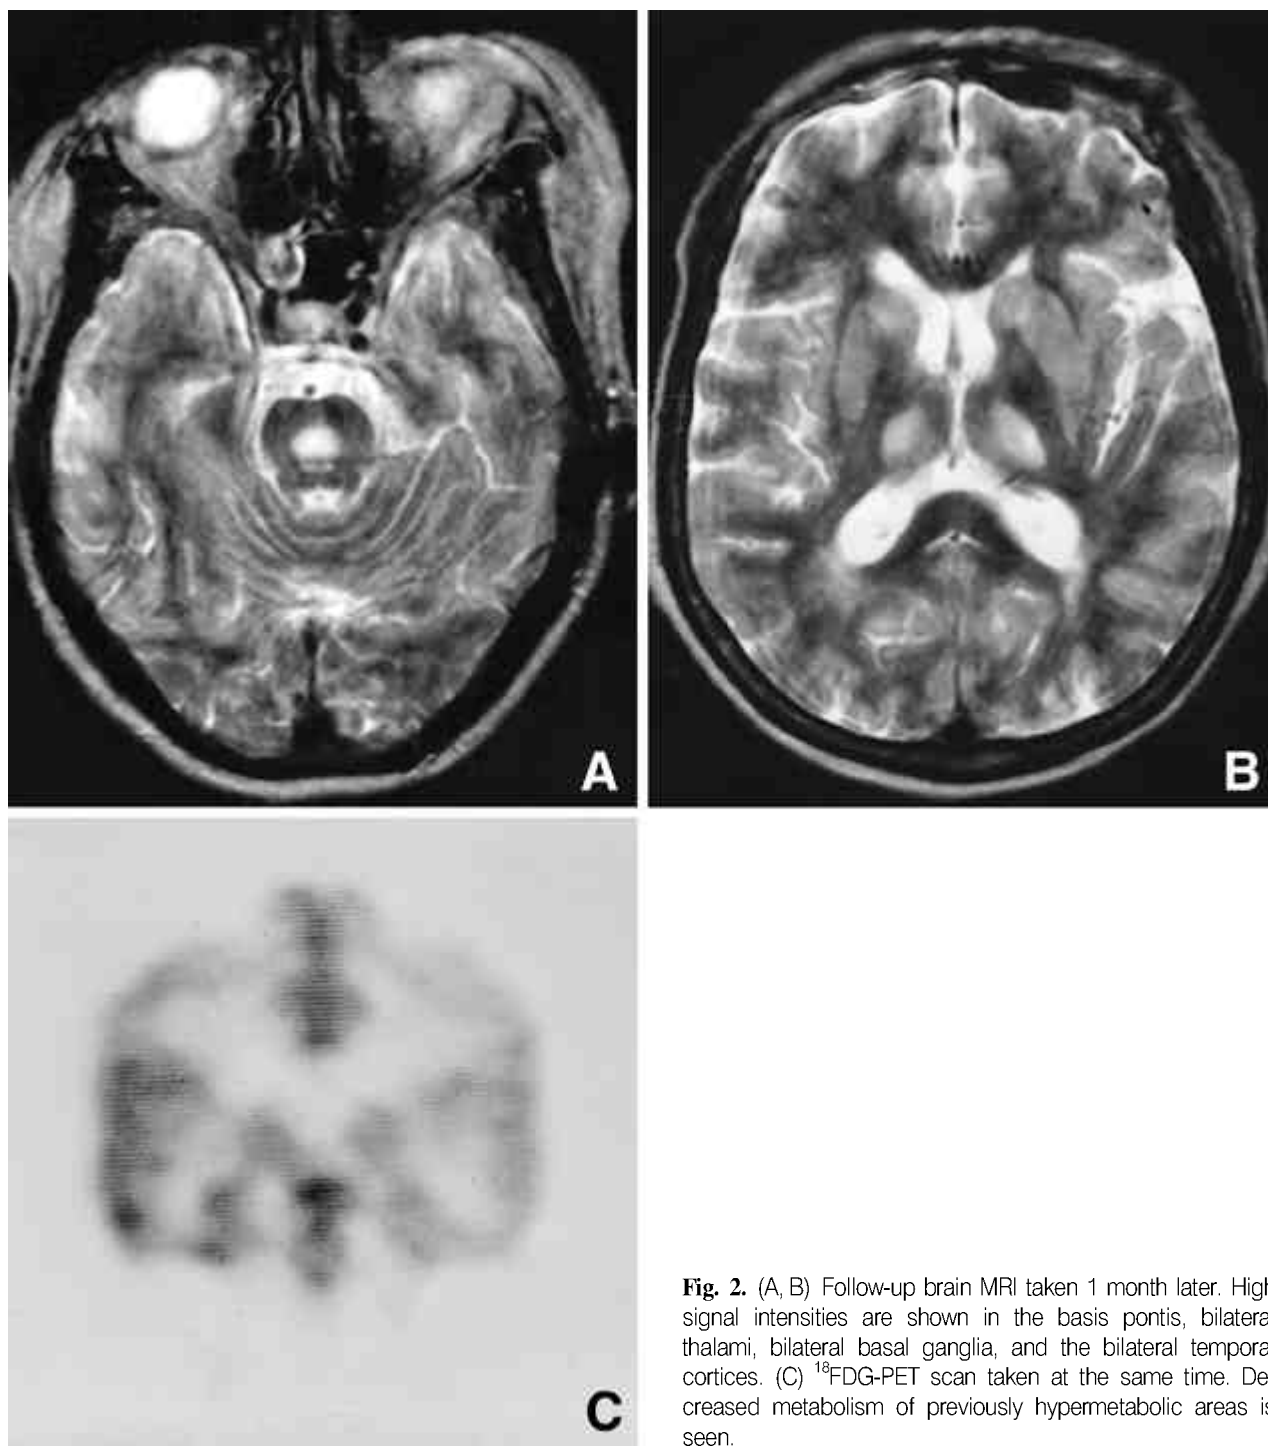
(A, B) Follow-up brain MRI taken 1 month later. High signal intensities are shown in the basis pontis, bilateral thalami, bilateral basal ganglia, and the bilateral temporal cortices. (C) ^{18}F FDG-PET scan taken at the same time. Decreased metabolism of previously hypermetabolic areas is seen.
